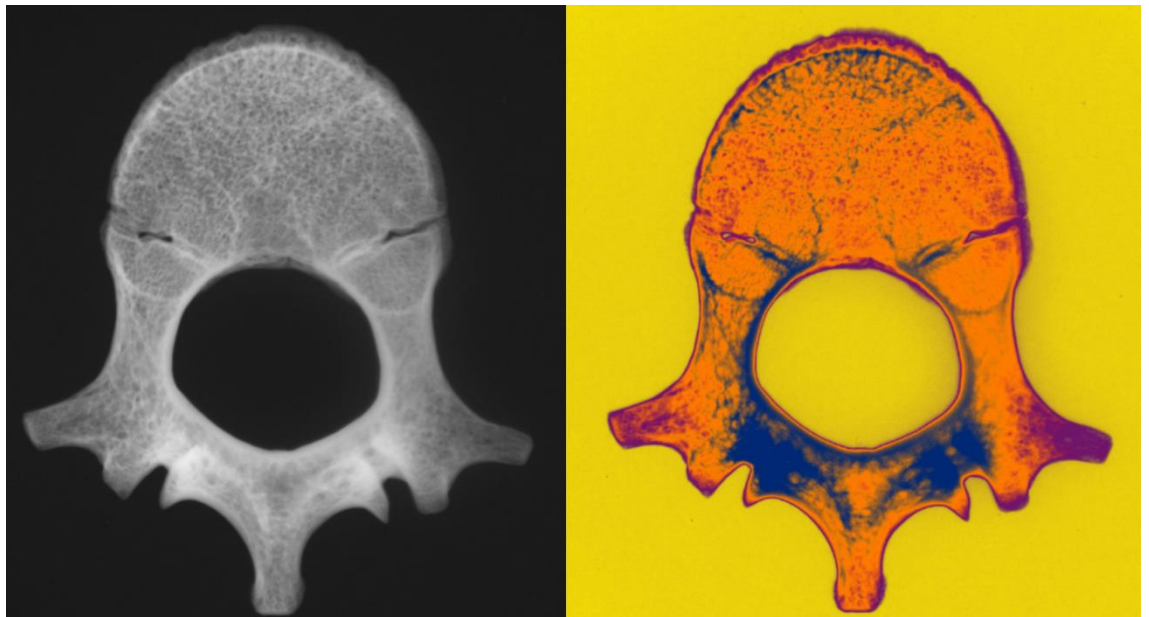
Left: Original digital radiograph of the 1st lumbar vertebra of individual SC-010, 4 years of age. Right: SC-010 L1 with gradient map.
